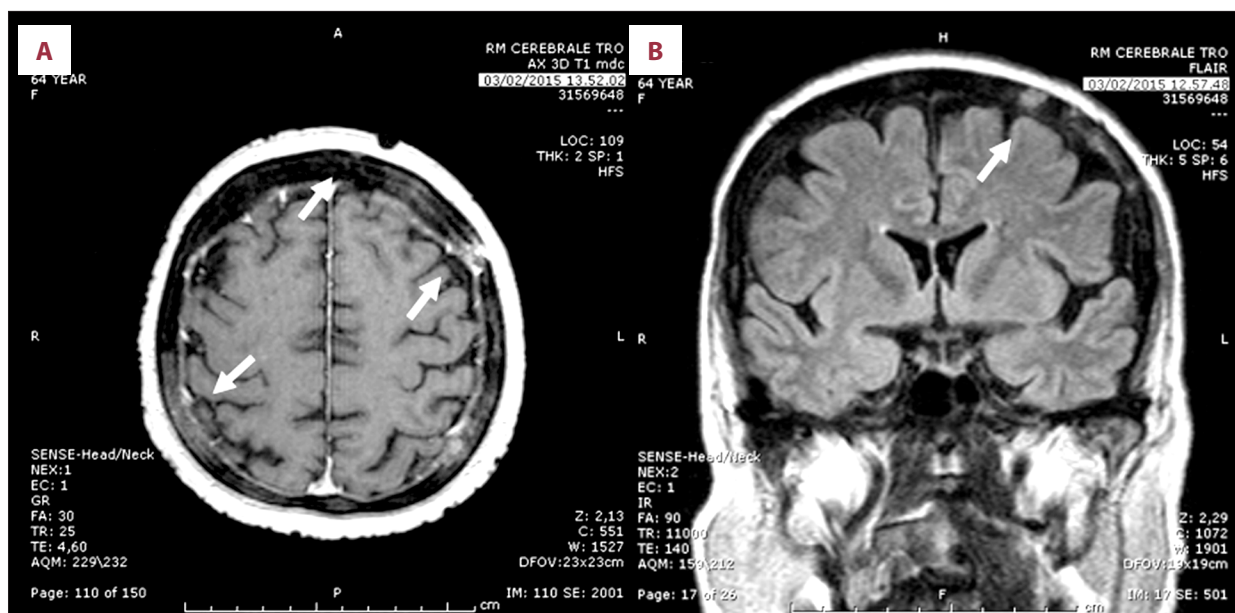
(A, B) The brain MRI performed after 6 months of metronomic capecitabine, confirming the diffuse bone and meningeal disease involvement, and showing initial response to the treatment and reduction in tumor vasculature.
